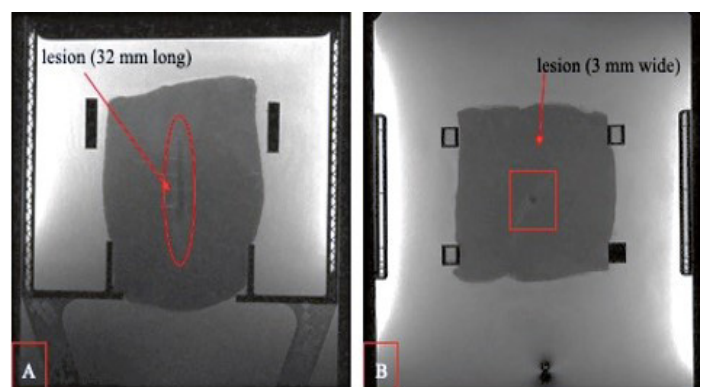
(A) High-resolution T2-W FSE MR image (axial plane), (B) High-resolution T2-W FSE MR image (coronal plane) obtained after applying acoustical power of 63 W, sonication time 30 s, frequency 1.1 MHz, d=50 mm, R=100 mm, focal depth= 45 mm.
